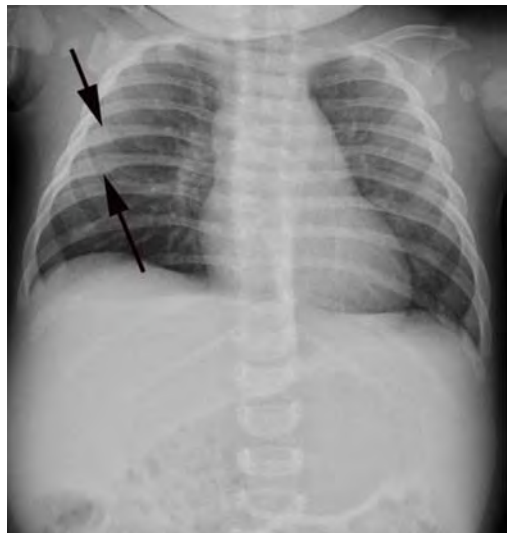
Multiple healing rib fractures (*arrows*) seen on X-ray (courtesy of Department of Radiology, Indiana University School of Medicine)
